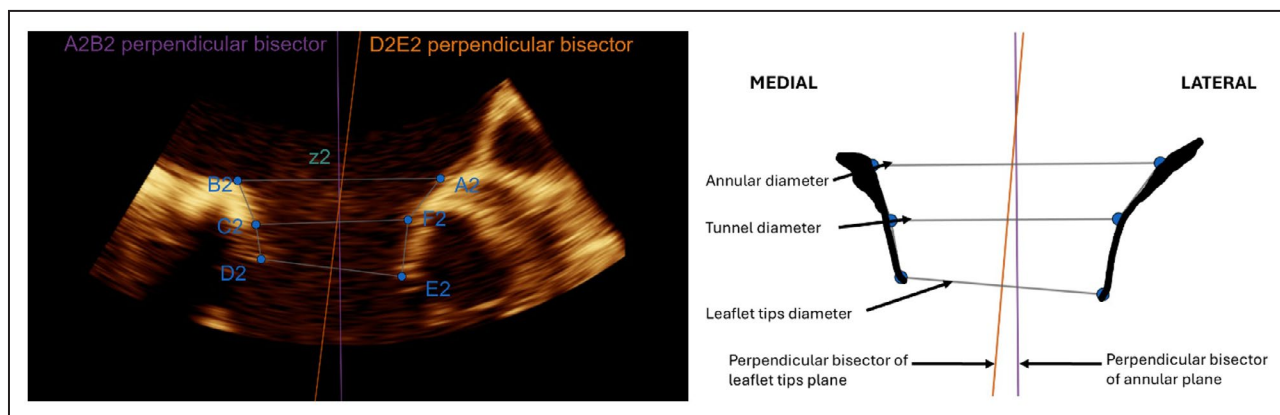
Intercommissural echocardiographic view.
